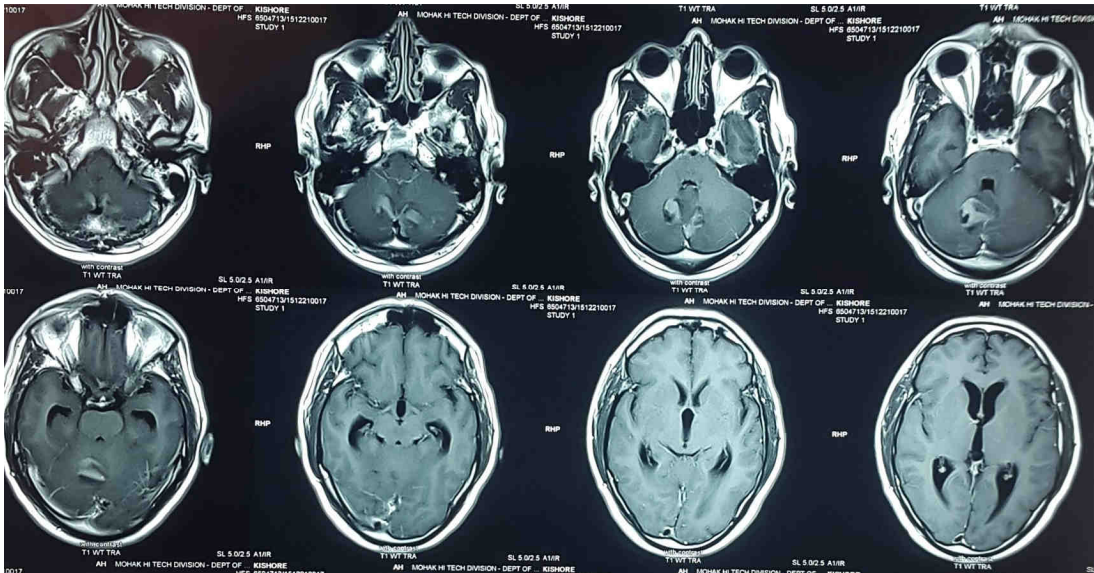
Post contrast MRI brain axial section showing heterogeneous intensity mass lesion in posterior fossa mainly involving midline
